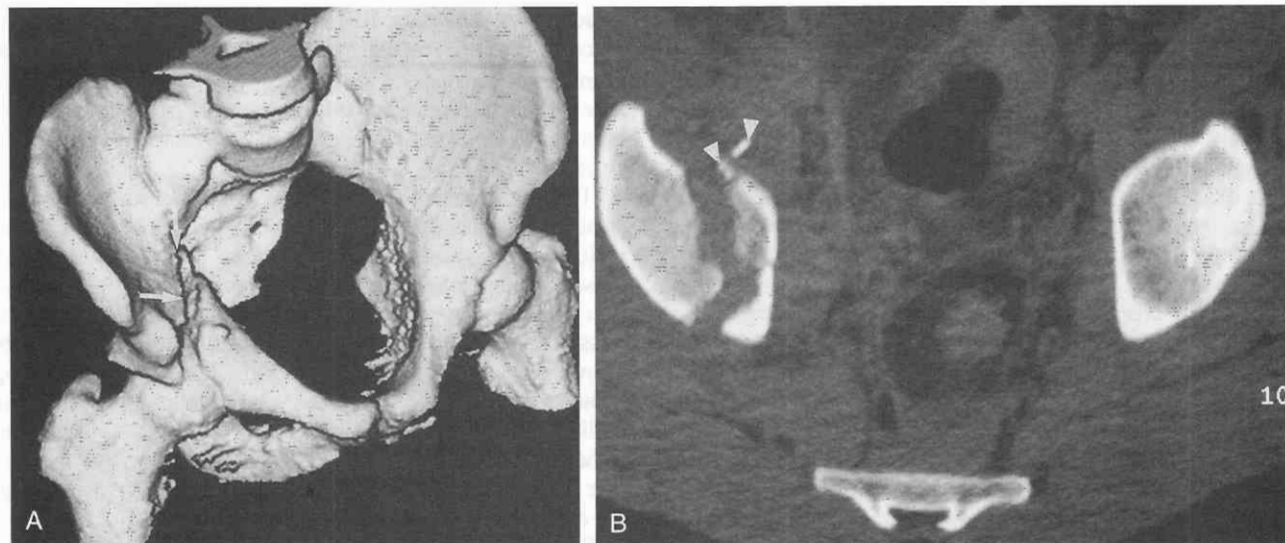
Acetabular fracture. Comminuted vertical fracture through the right acetabular roof. A, Surface-shaded 3D CT scan viewed obliquely from above shows the fracture line (arrows). B, Axial section from the same examination volume shows fine detail of small fracture fragments (arrowheads) not appreciated on the 3D CT scan.
